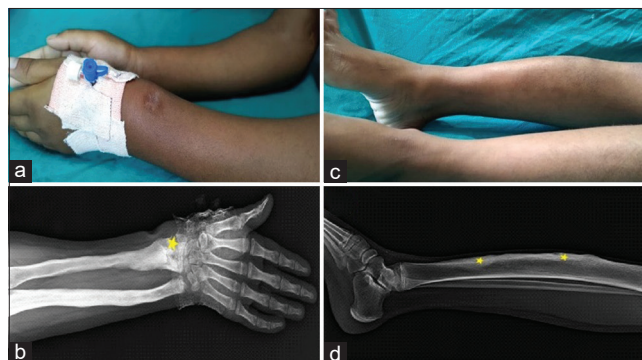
(a) Healed gummata and deformity of left forearm, (b) osteolytic sclerotic lesion in X-ray of the left wrist, (c) Sabre shin deformity, (d) anterior bowing with cortical thickening, mild periosteal reaction in X-ray of the right lower limb
